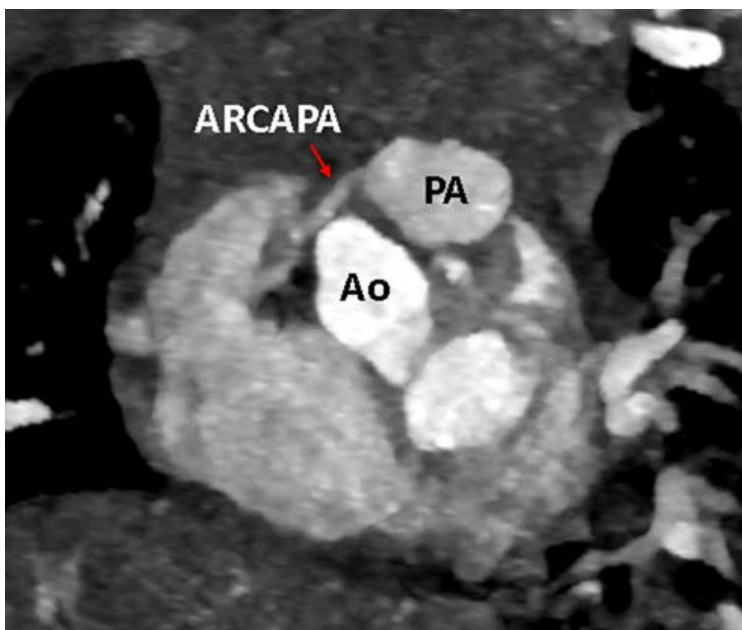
CT Image for Case 1: ARCAPA. (ARCAPA = Anomalous origin of the right coronary artery from the pulmonary artery; Ao = Aorta; PA = pulmonary artery)
